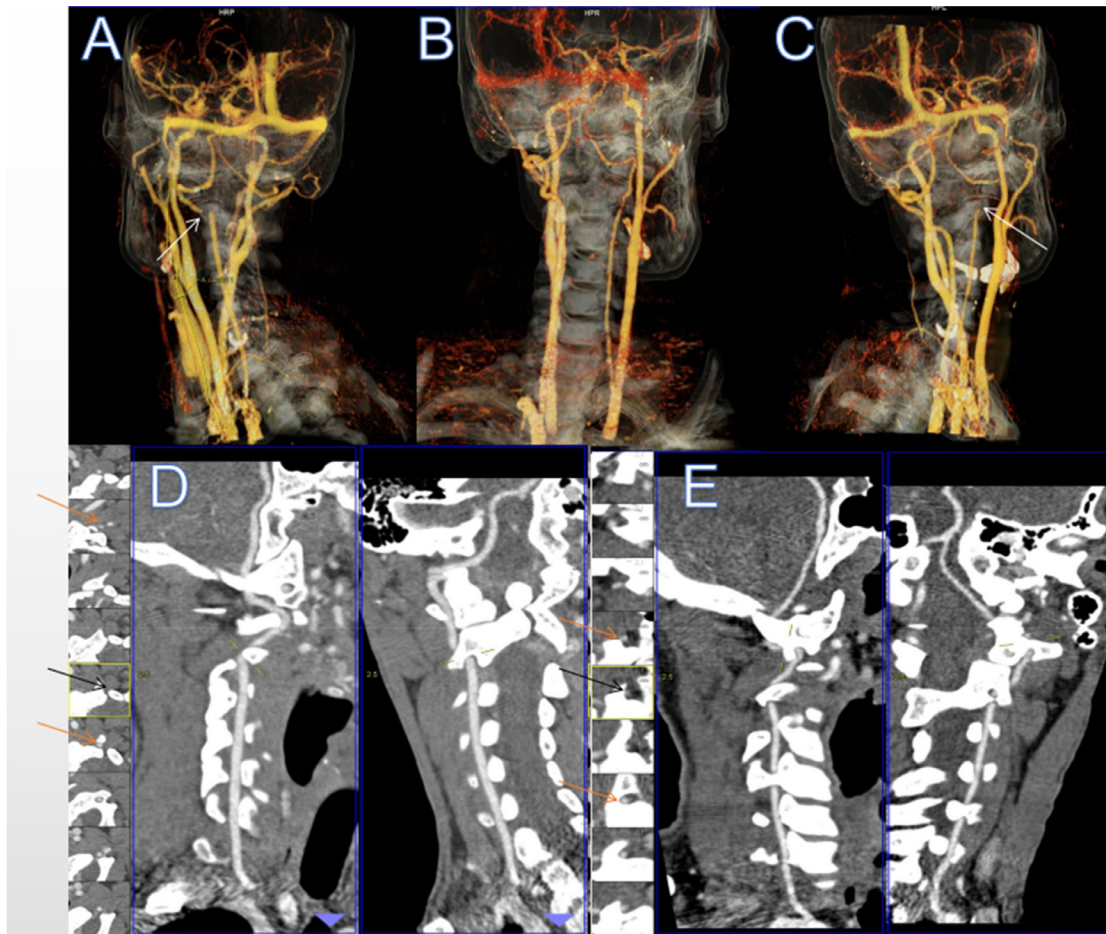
VR and MPR images of CT angiogram of the patient turning his head to one side showed contralateral C2 segment occlusion. (A) VR image of CT angiogram of the patient turning right 90° showed C2 segment occlusion of the left vertebral artery (white arrow). (B) VR image of CT angiogram of the patient in the neutral position showed good bilateral vertebral artery development. (C) VR image of CT angiogram of the patient turning left 90° showed C2 segment occlusion of the right vertebral artery (white arrow). (D) MPR image of CT angiogram of the patient turning right 90° showed C2 segment occlusion of the left vertebral artery (black arrow), but the other vascular segments were normal (yellow arrow). (E) MPR image of CT angiogram of patient turning left 90° showed C2 segment occlusion of the right vertebral artery (black arrow), but the other vascular segments were normal (yellow arrow). MPR, multiplanar reconstruction; VR, virtual reality. (Color version of the figure is available online.)
